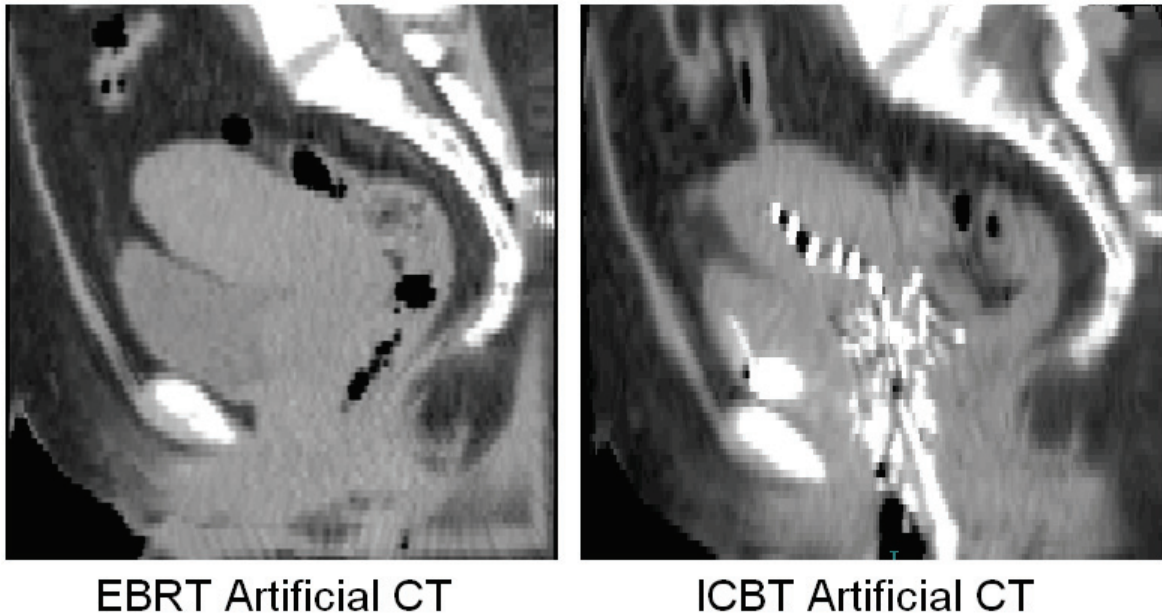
Example of EBRT Artificial CT and ICBT Artificial CT generated using $D_{\max} = 2$. Since our choice for D_{\max} is not large, the deformation between the two images is not as severe.
